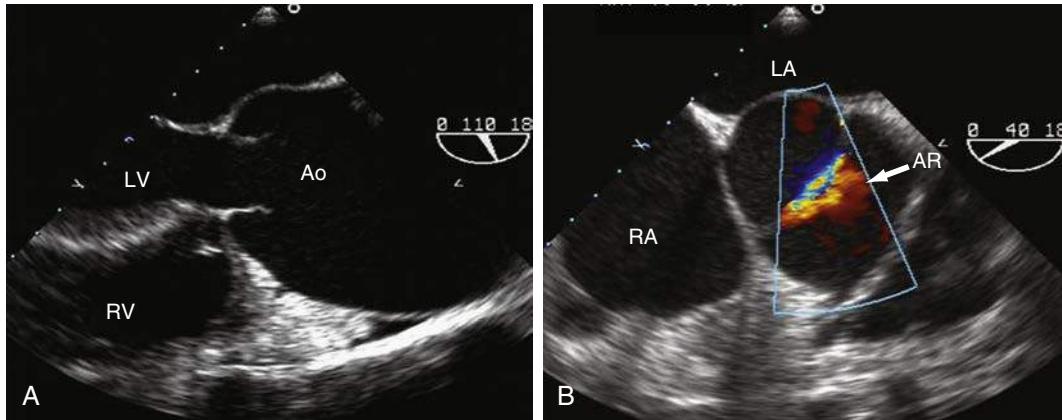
A, Two-dimensional transesophageal echocardiogram (2D TEE): a bicuspid aortic valve with a severely dilated ascending aorta. B, Color Doppler shows the aortic regurgitation jet through the aortic valve (white arrow). Ao, Aorta; AR, aortic regurgitation; LV, left ventricle; LA, left atrium; RA, right atrium; RV, right ventricle.
